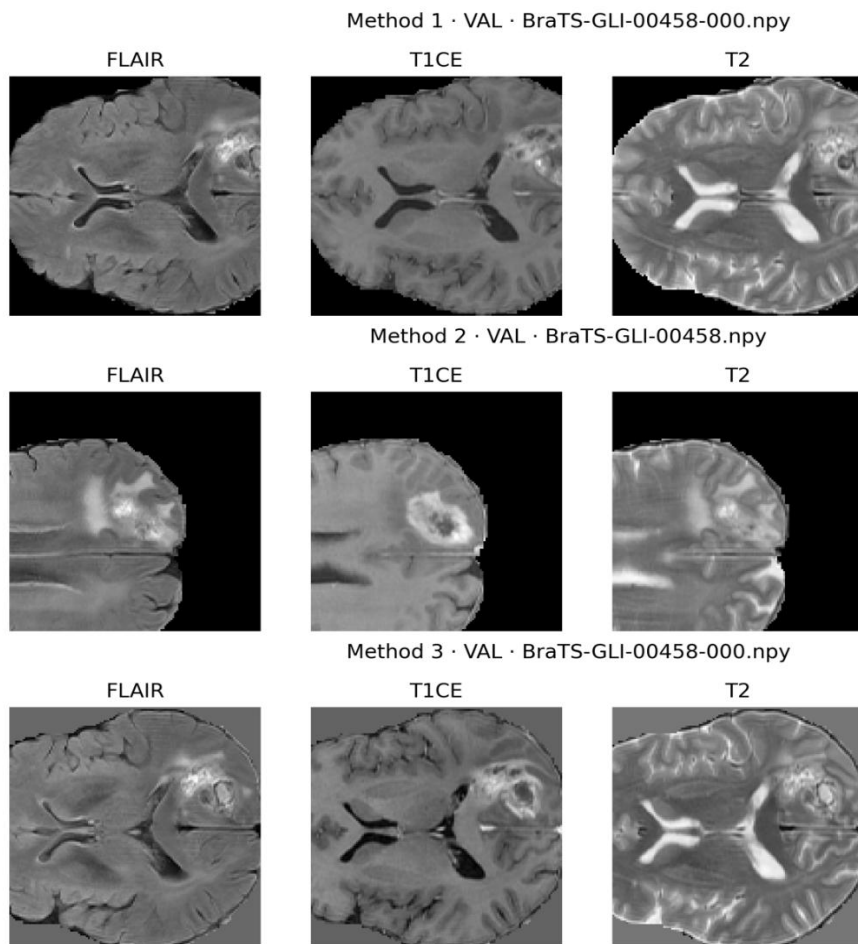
Images from the validation set after preprocessing with Methods 1, 2, and 3. Each row shows FLAIR, T1GD, and T2 with the corresponding segmentation labels.
